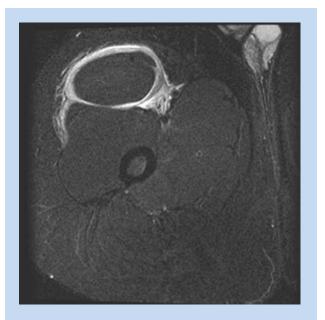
Axial fast-spin echo inversion recovery T2-weighted image through right proximal thigh.
